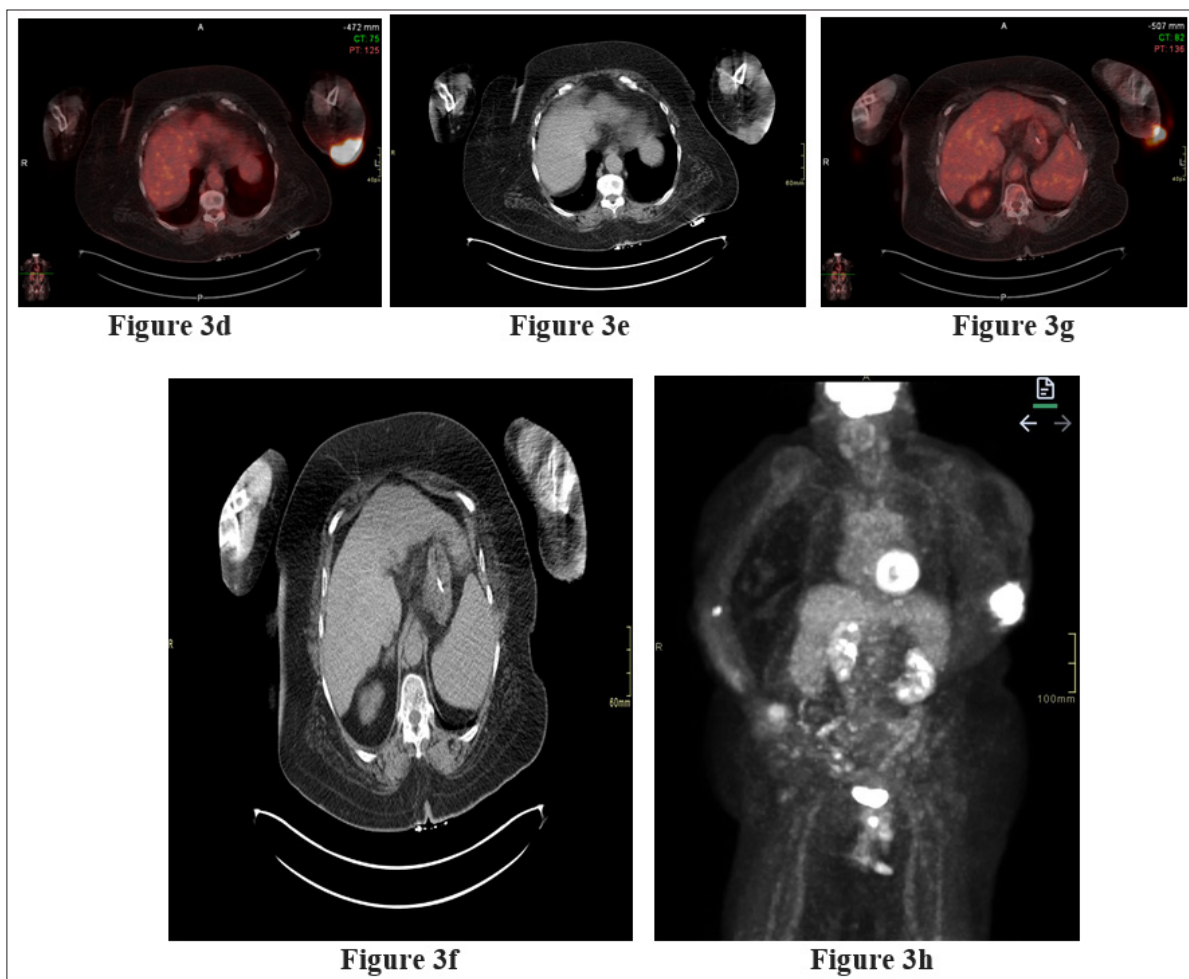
d,e,f,g,h: Initial fluorodeoxyglucose (FDG) PET/CT from 1/13/2023
